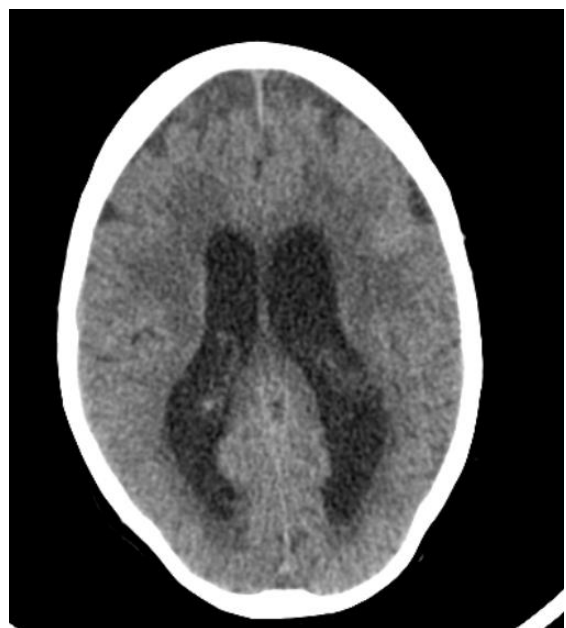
CT scan on coronal view showing hydrocephalus.
